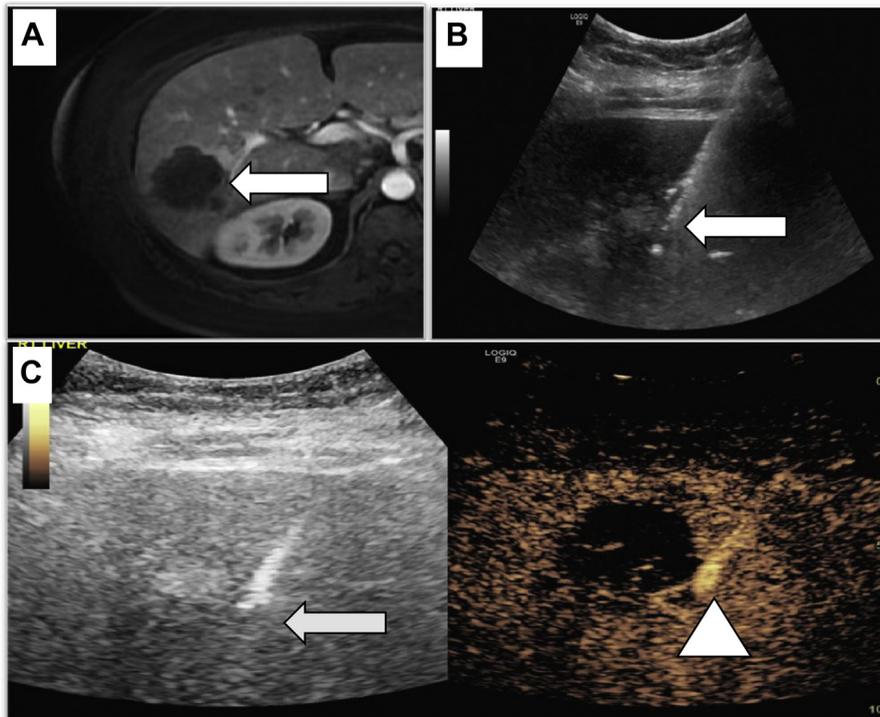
Percutaneous liver biopsy in a 59-year-old woman with thyroid cancer and an enlarging right liver mass with central necrosis (A, arrow). An initial biopsy attempt was unsuccessful due to the necrotic nature of the lesion (B, arrows). Ultrasound contrast was administered on the second biopsy attempt, which differentiated the hypochoic necrotic tumor from the enhancing viable tumor (C, arrowhead) thus facilitating successful needle biopsy of the viable region (C, arrow).
